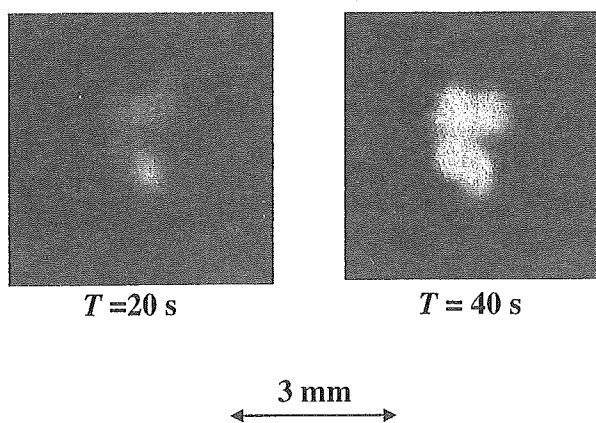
Images of X-ray source with changes in exposure time.
